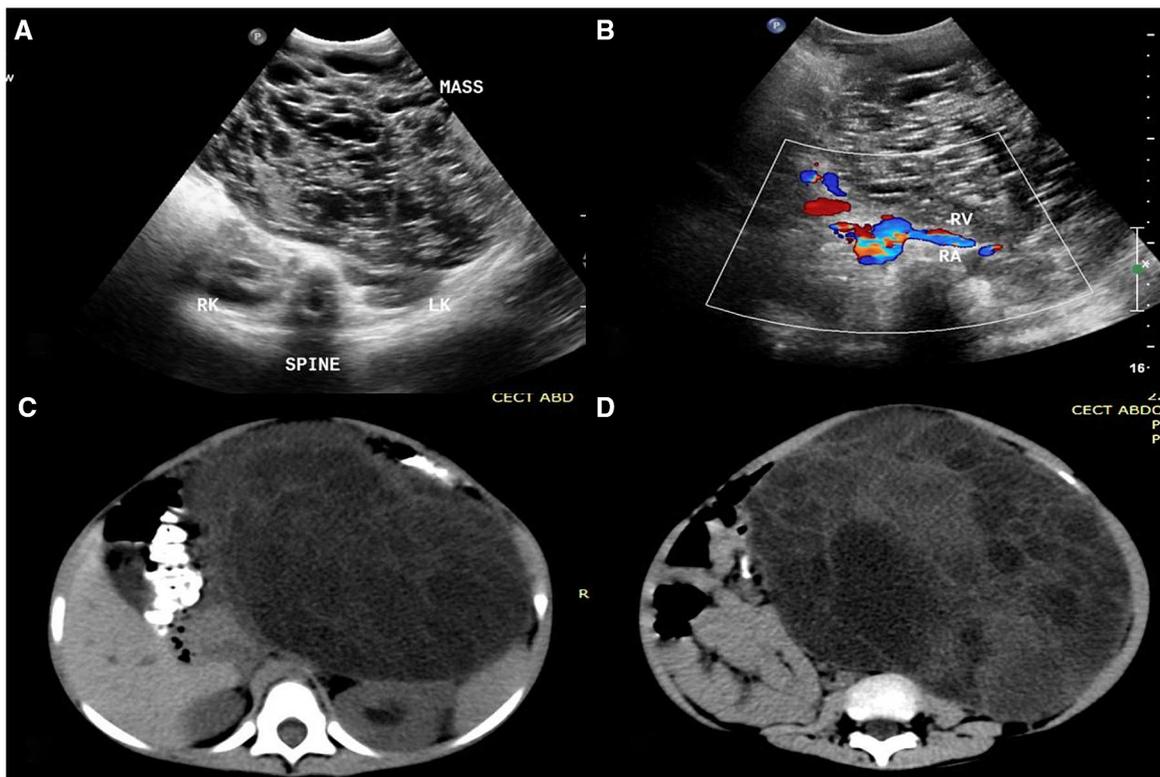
A–L Imaging studies in a 4-year-old boy, with palpable left renal mass. The ultrasound (A, B) and CT study (C–H) show a large multilocular cystic tumor arising from lower pole of left kidney. The claw sign is seen in F. There is absence of solid component; however, faint enhancement of septa is seen (G; white arrows). The MRI
